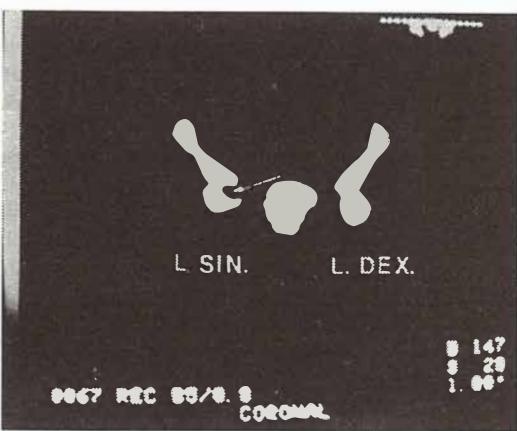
Three different SPECT images. More precise delineation of the photon deficient area and activity analysis of the growth plate with tomographic slices than with planar and pinhole scintigraphy
